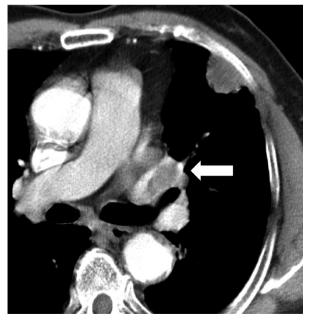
Conventional chest computed tomography showing a filling defect in the left pulmonary artery
